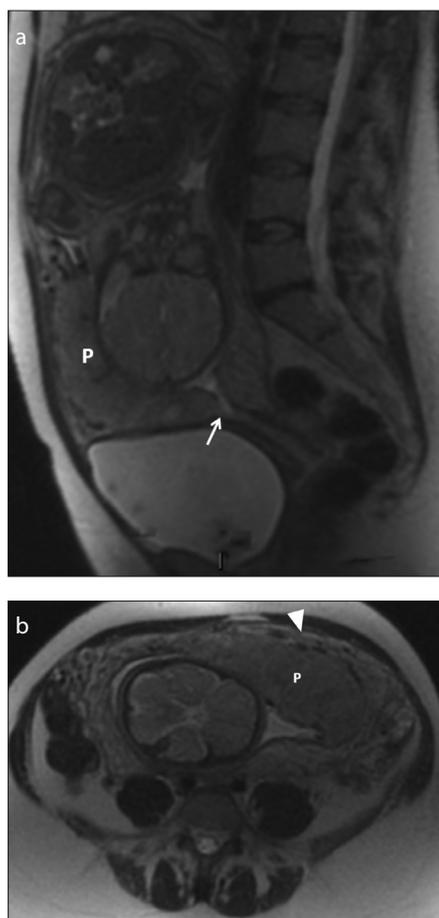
a, b. MRI showing normal placenta in a 39-year-old woman at 36 weeks of gestational age. Sagittal (a) and axial (b) T2-weighted images show normal “pear shaped” uterus, with the placenta (P) extending to the edge of internal os (arrow) without covering it. The placenta is homogeneous with thin hypointense regular lines that represent septa. The three distinct layers of myometrium are visible, with the inner and outer layers showing as hypointense and the inner one showing as intermediate intensity (arrowhead).
